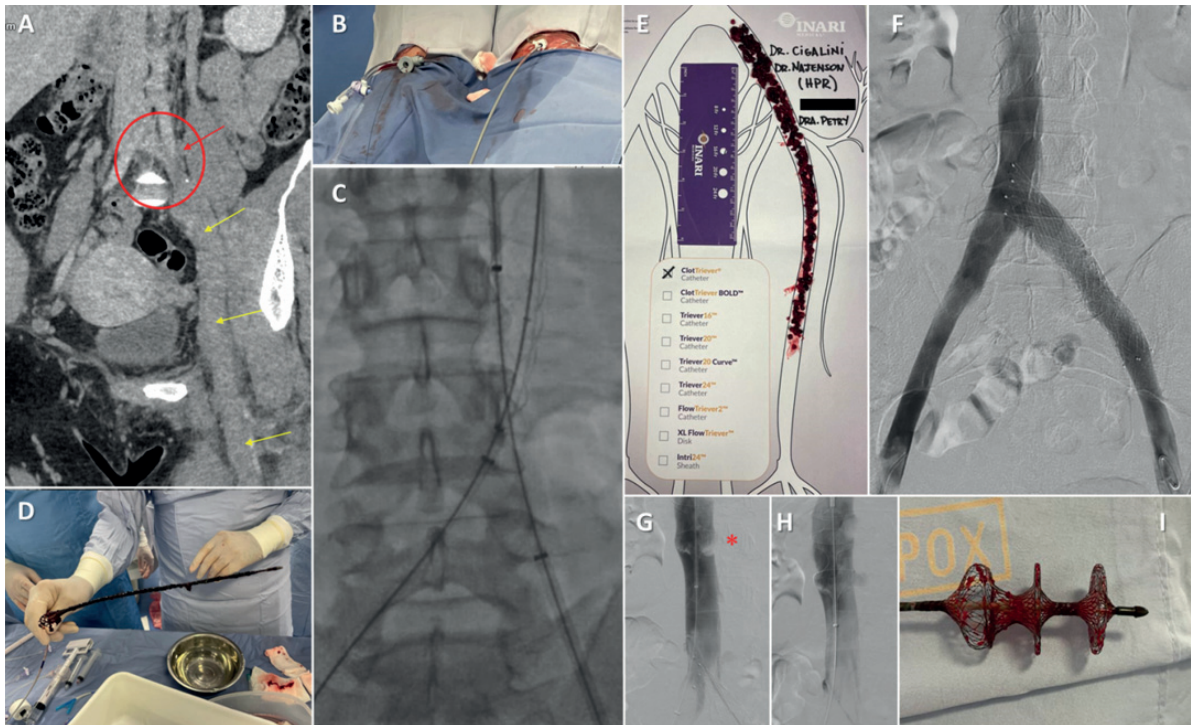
A) CT angiography revealing extensive thrombosis in MTS. B) Bilateral popliteal puncture: left for the thrombectomy with ClotTriever and right for the deployment of embolic protection discs. C) Thrombectomy with the ClotTriever device, with the coring element deployed below the embolic protection discs. D-E) Abundant thrombi extracted. F) Final outcome after implantation of a dedicated self-expanding stent. G-H) Embolization of thrombi (*retained by the embolic protection discs) subsequently aspirated without incidents. I) FlowTriever with retained thrombi.
